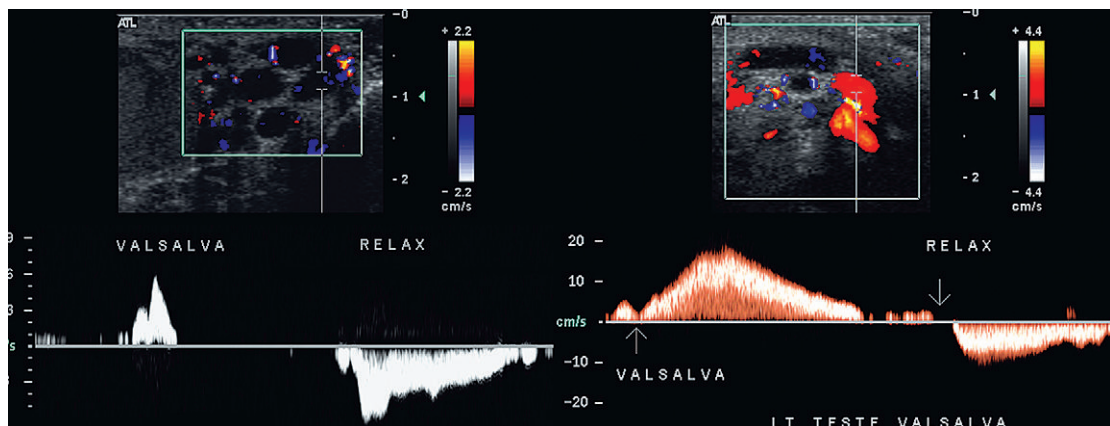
Spectral Doppler tracings of the left spermatic cord in two patients with a known varicocele. The tracings were obtained as a Valsalva manoeuvre was initiated, maintained, and released. The first patient has a brief reversal of flow at the start of Valsalva; blood below the distal most valve is forced downward, but then because of valve patency, the flow reversal stops. Upon relaxation of the Valsalva, flow surges forward again. The second patient initiates reversal of flow and then maintains persistent flow reversal as renal venous outflow is shunted down the gonadal vein because of the high pressure in the thorax. As pressure builds within the testicle, flow progressively slows until the point of relaxation at which time flow surges forward.
